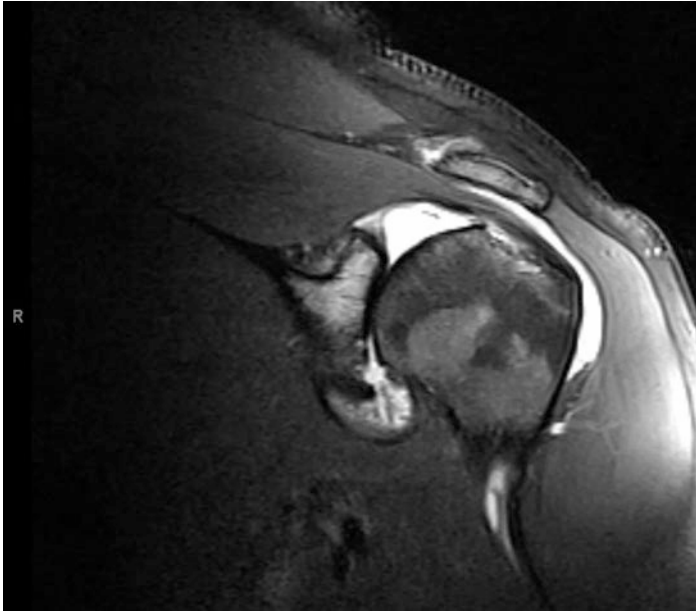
Coronal T2-weighted MR image demonstrating chondral damage with extensive synovitis and large effusion
